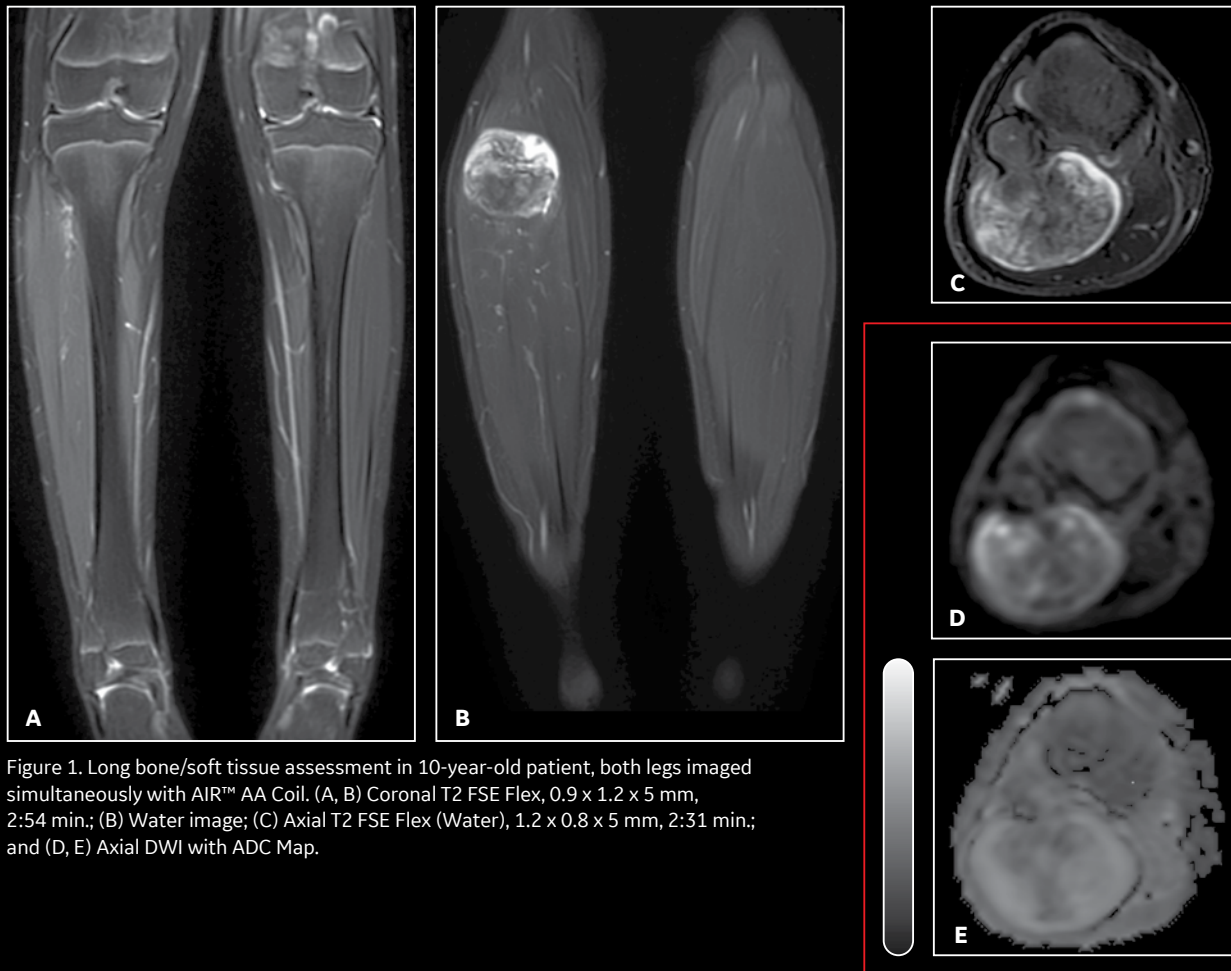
Long bone/soft tissue assessment in 10-year-old patient, both legs imaged simultaneously with AIR™ AA Coil. (A, B) Coronal T2 FSE Flex, 0.9 x 1.2 x 5 mm, 2:54 min.; (B) Water image; (C) Axial T2 FSE Flex (Water), 1.2 x 0.8 x 5 mm, 2:31 min.; and (D, E) Axial DWI with ADC Map.
